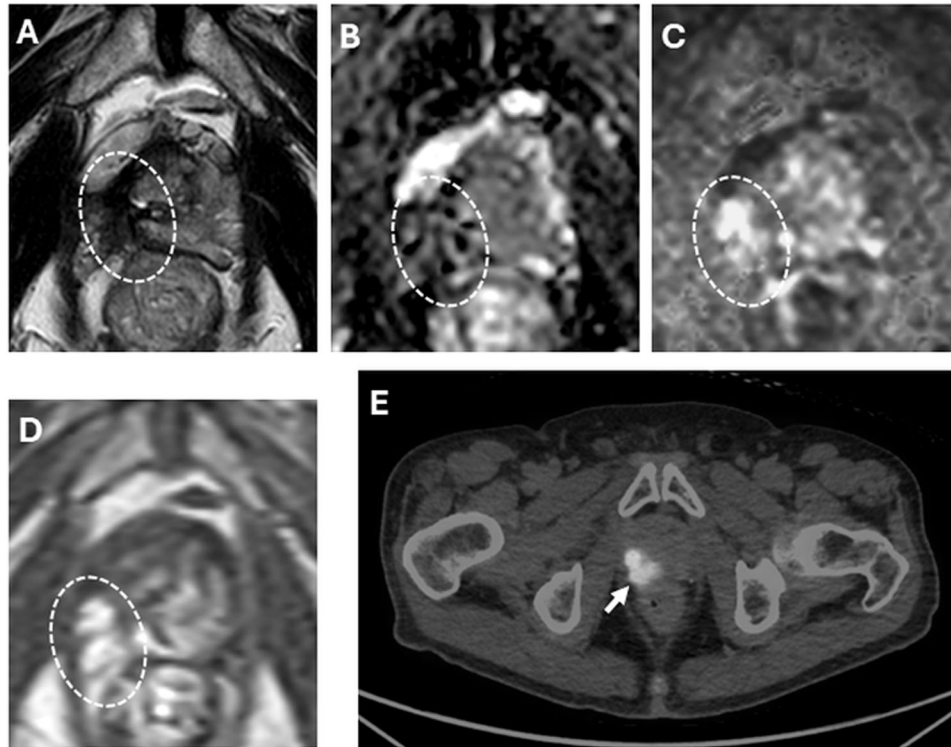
Multiparametric MRI and PSMA PET/CT showing recurrence 12 months after focal HIFU. Axial T2W MRI (A), ADC map (B), b1500 DWI MRI (C) and DCE MRI (D) demonstrate right-sided recurrent lesion (dashed circle), which also demonstrates tracer uptake on 18F-DCFPyL PET/CT (arrow) (E).
